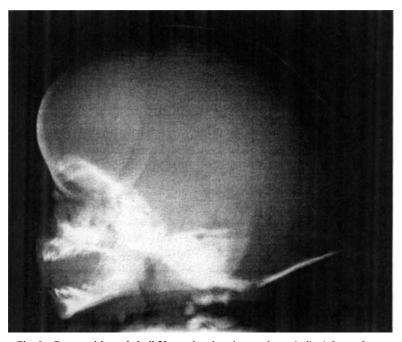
Postnatal lateral skull X-ray showing the scaphocephalic deformation
